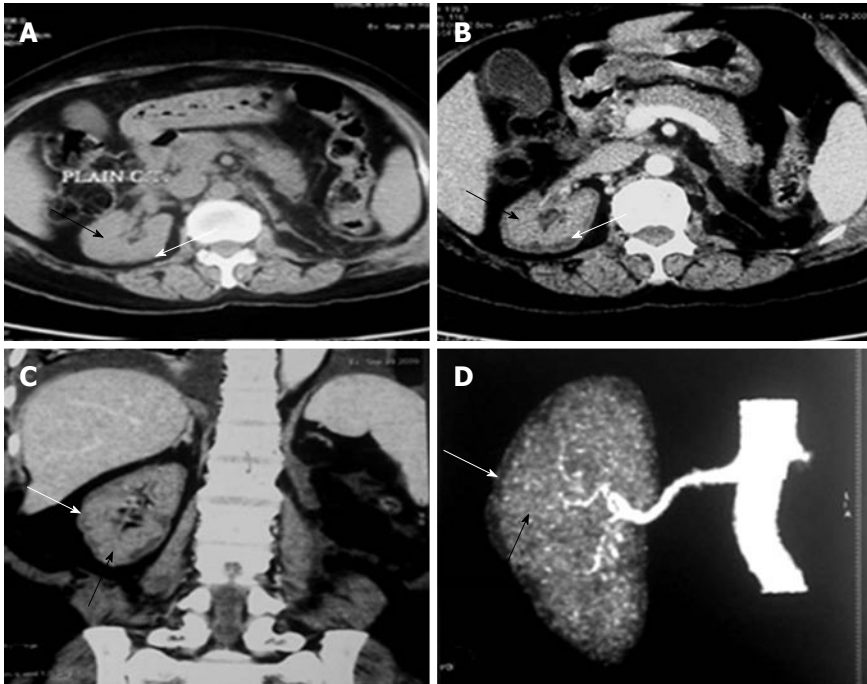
Renal cortical necrosis in a living kidney donor. Adapted from Prakash *et al.*^[32]. Non-contrast (A) computed tomography (CT) scan of abdomen at the level of right hilum showing hypoattenuating peripheral cortical rim (white arrow) as compared to the inner isoattenuating parenchyma (black arrow). On contrast-enhanced axial (B) and coronal (C) scans the central viable parenchyma enhances (black arrow) while the peripheral necrotic cortex does not show any significant enhancement (white arrow). Overall picture is suggesting renal cortical necrosis. The corresponding appearance is also well noted CT Angiogram (D) showing absent uniform nephrogram (white arrow).
